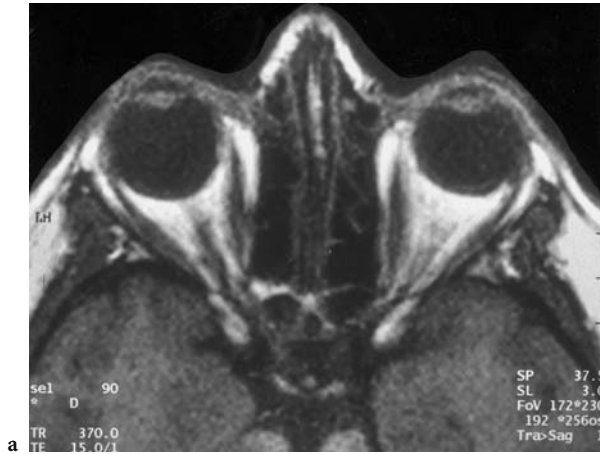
A 46-year-old woman with symptoms of recurrence of known Graves' disease. Diagnosis: acute Graves' disease. MRI: a Axial T1-weighted view without apparent evidence of enlarged rectus muscles. b Coronal T1-weighted view demonstrating moderate enlargement of all rectus muscles, but slight thickening of the left inferior rectus muscle. c Axial view of octreotide/MR-matching, demonstrating coating of both entire orbits with octreotide. *Above:* octreotide scan, *middle:* corresponding MR (3D) slices, *below:* matched slices. (c with the permission of Dr. Förster, Institute of Nuclear Medicine, Medical School, University of Mainz)
